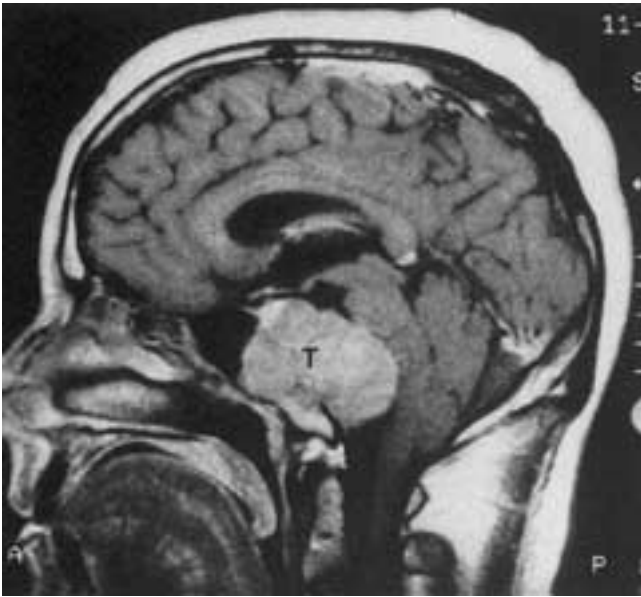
Chordoma. T1-weighted image after contrast administration shows the tumor (T), with fairly homogeneous intermediate enhancement without cystic areas.
